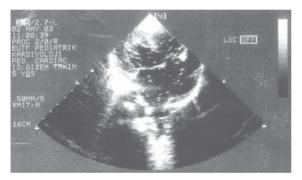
A "bubble" on contrast echocardiogram (apical four-chamber view). Stream of microbubbles filling the left atrium following systemic venous injection was shown.
